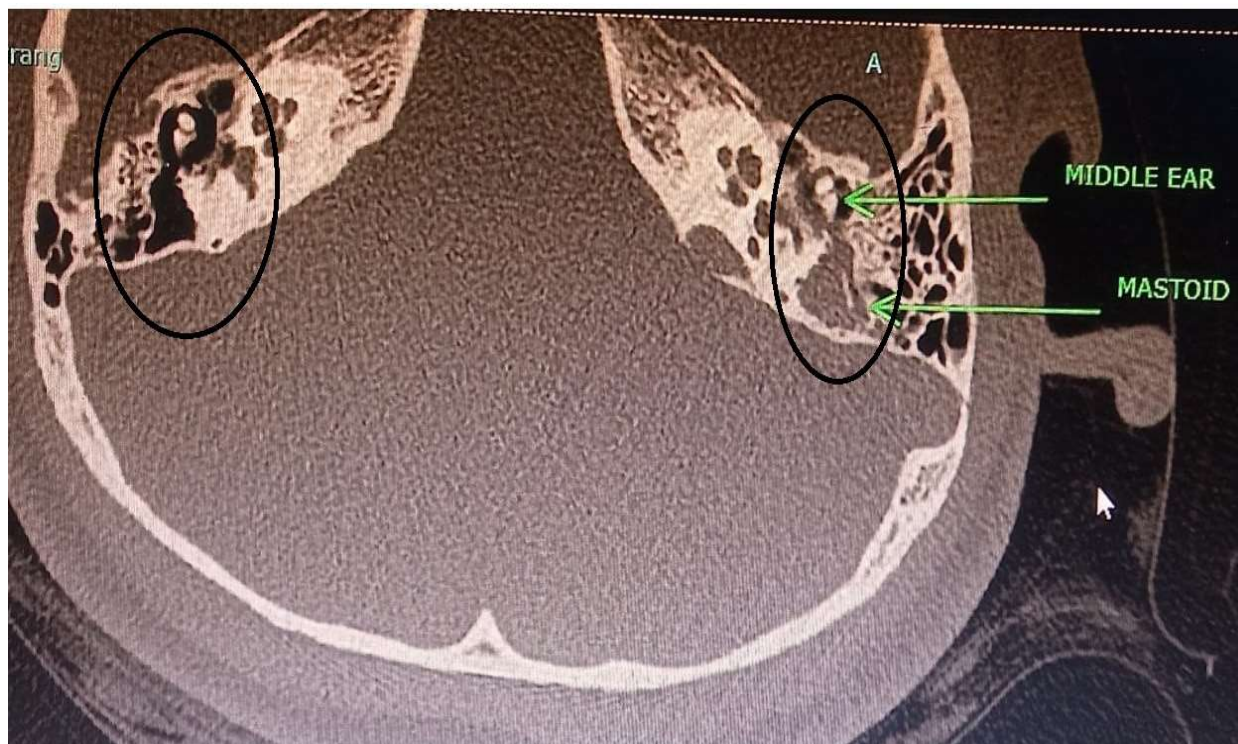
High-resolution computed tomography of temporal bone showing the collection of fluid (blood) in the left middle ear for comparison right ear is also shown in the image
